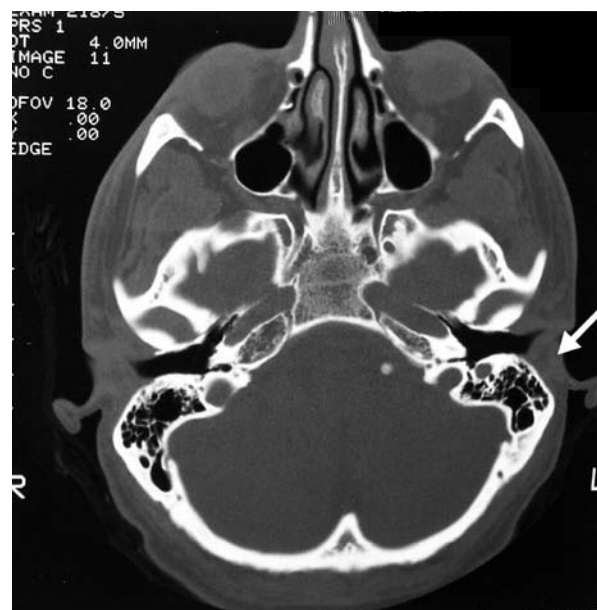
Case 2: high resolution axial CT. Enlargement with clear margins of bony walls of third portion of left Fallopian canal.
